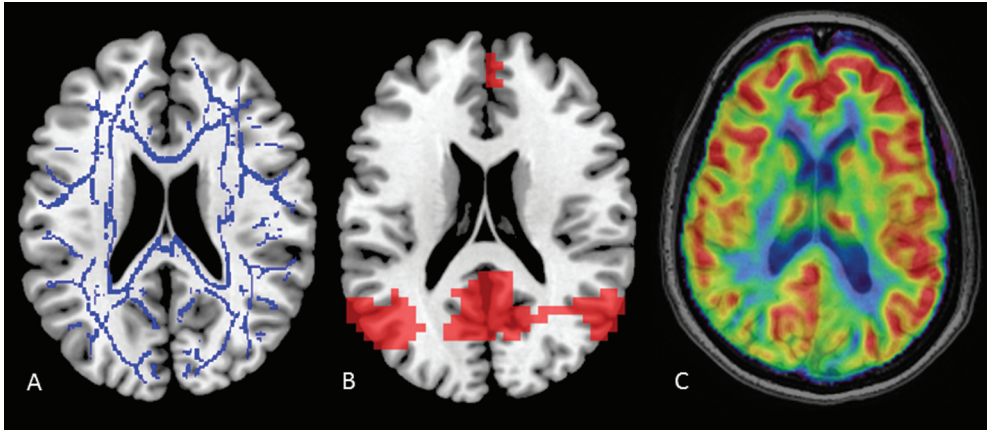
Axial images of (A) a white matter skeleton created by post-processing of diffusion tensor imaging, (B) resting state functional magnetic resonance imaging, and (C) arterial spin labelling in healthy participants. The white matter skeleton is depicted in blue (A). Default mode network functional connectivity of the inferior parietal lobules, posterior cingulate cortex/precuneus, and medial prefrontal cortex is shown in red (B). Grey matter regions with the highest perfusion are shown in red (C).
